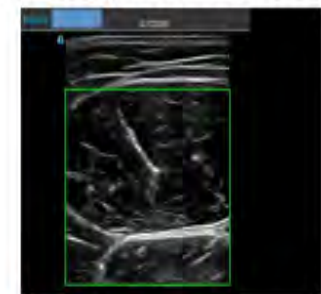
Muscle glycogen scores via ultrasound.
